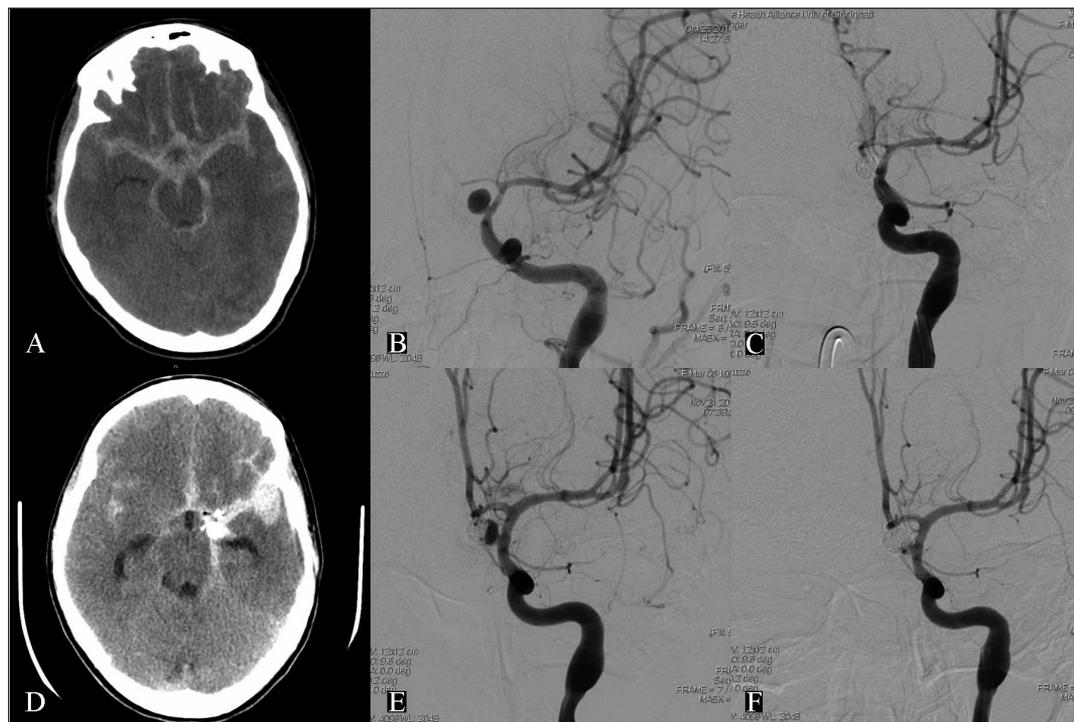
A) Head CT reveals Fisher grade 3 subarachnoid hemorrhage. B) Cerebral angiography demonstrates a 6-mm left posterior communicating artery aneurysm. C) Post-treatment cerebral angiography shows complete aneurysm obliteration after stent-assisted coiling. D) Head CT, 3 weeks later, reveals recurrent Fisher grade 3 subarachnoid hemorrhage predominating in the left sylvian fissure. E) Cerebral angiography demonstrates recurrence of the coiled left posterior communicating artery aneurysm. F) Post-treatment cerebral angiography shows subtotal aneurysm obliteration after repeat coiling.
